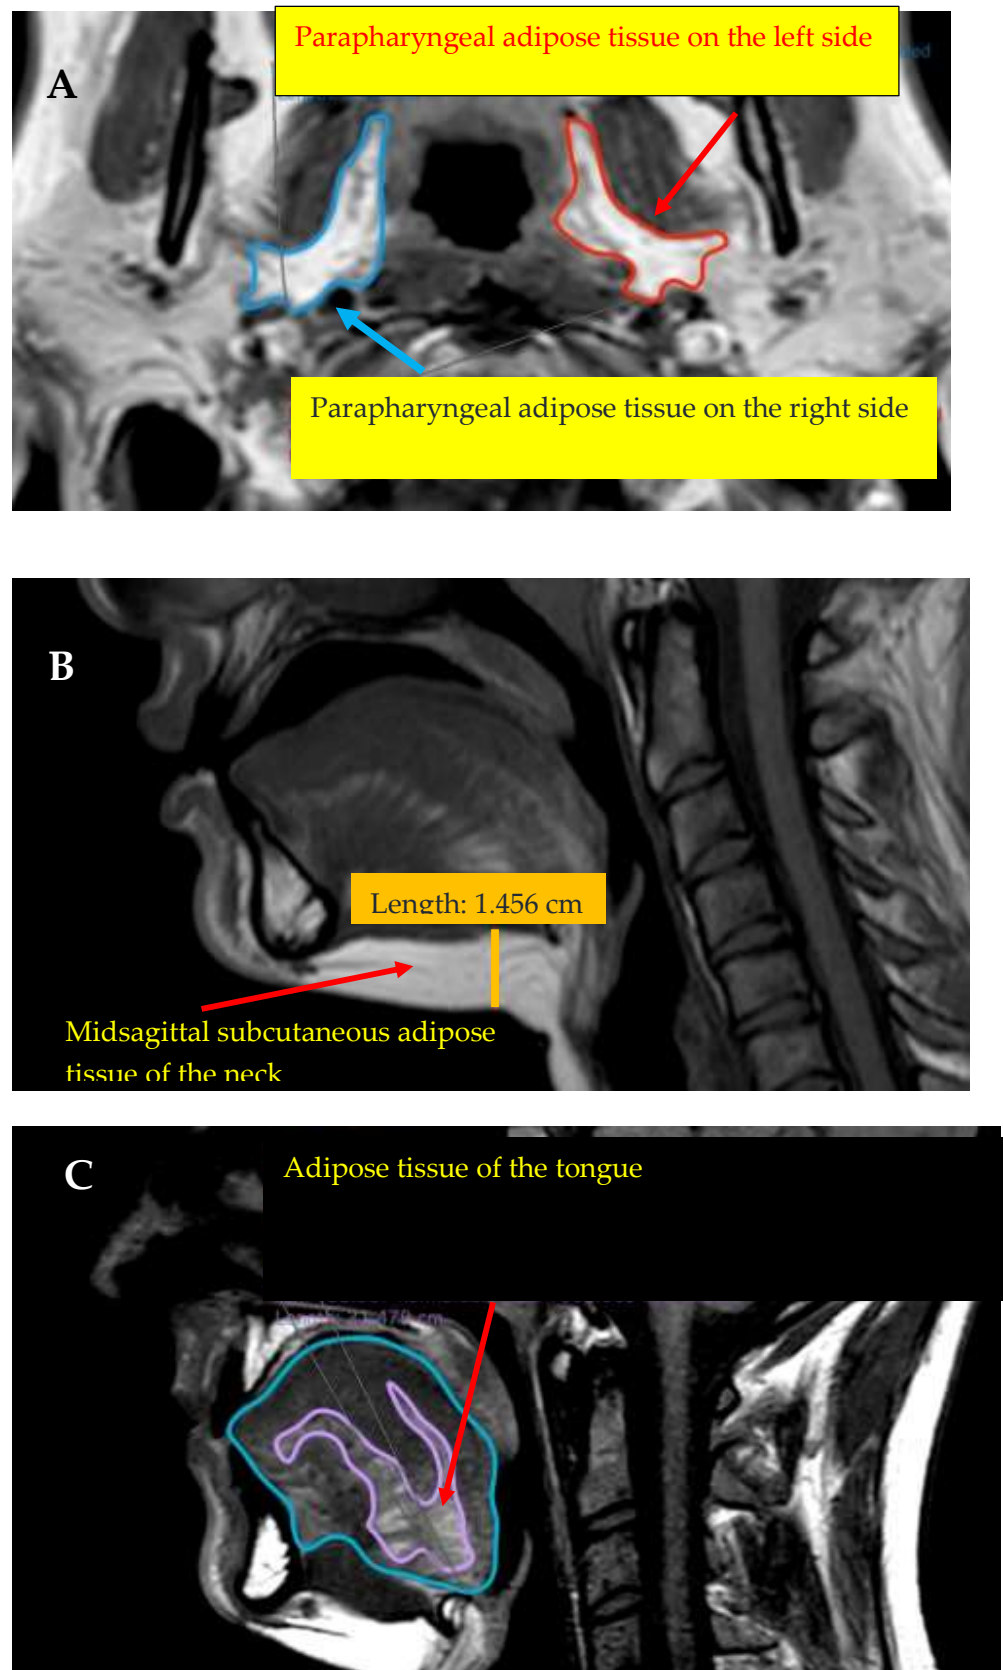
(A) T1-weighted measurements in the axial plane showing parapharyngeal adipose tissue on the left and right sides; (B,C) midsagittal axis of the T1-weighted MRI scans showing the midsagittal subcutaneous adipose tissue of the neck and adipose tissue of the tongue (taken from our data).
